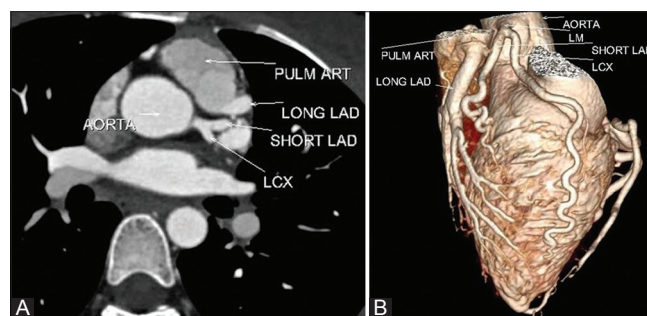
(A and B): (A) Axial CT coronary angiogram image showing origin of long LAD from the pulmonary trunk and of left main coronary artery from the aorta, with its bifurcation into short LAD and circumflex artery (B) 3D volume-rendered CT angiogram image showing origin of long LAD from the pulmonary trunk with the origin of short LAD from the left main coronary artery
